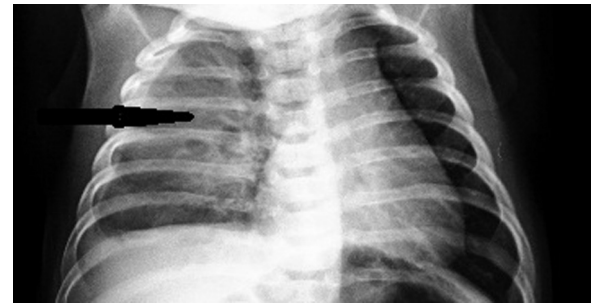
Chest x-ray showing consolidation in the right lung with air bronchograms and hyper-infiltration of the left lung.
